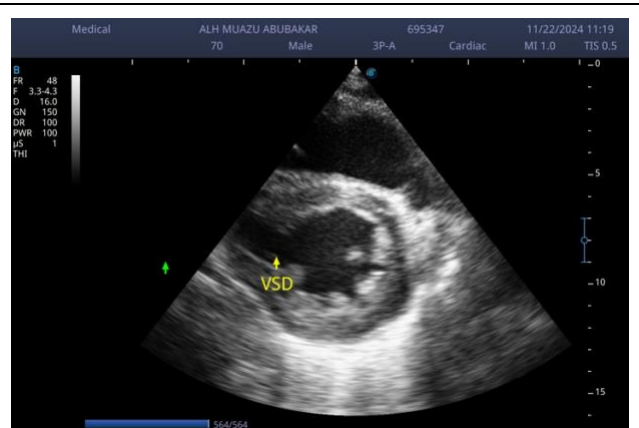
Second parasternal short axis view also showed post-MI ventricular septal defect (VSD) along the interventricular septum.
